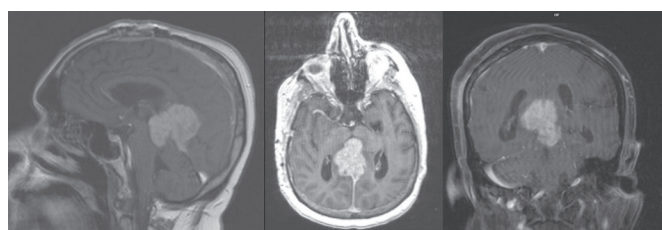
T1-weighted sagittal (left), transverse three-dimensional T1-weighted with gradient-echo imaging (centre) and coronal T1-weighted with fat suppression (right) brain MRI images roughly 1 month after initial presentation from the referring medical facility.
